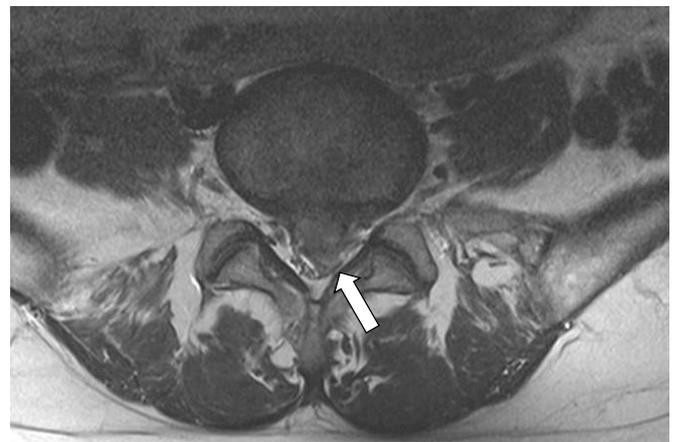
Axial T2-weighted magnetic resonance image showing herniated nucleus pulposus at the L5–S1 level (arrow) compromising the thecal sac during pregnancy.
